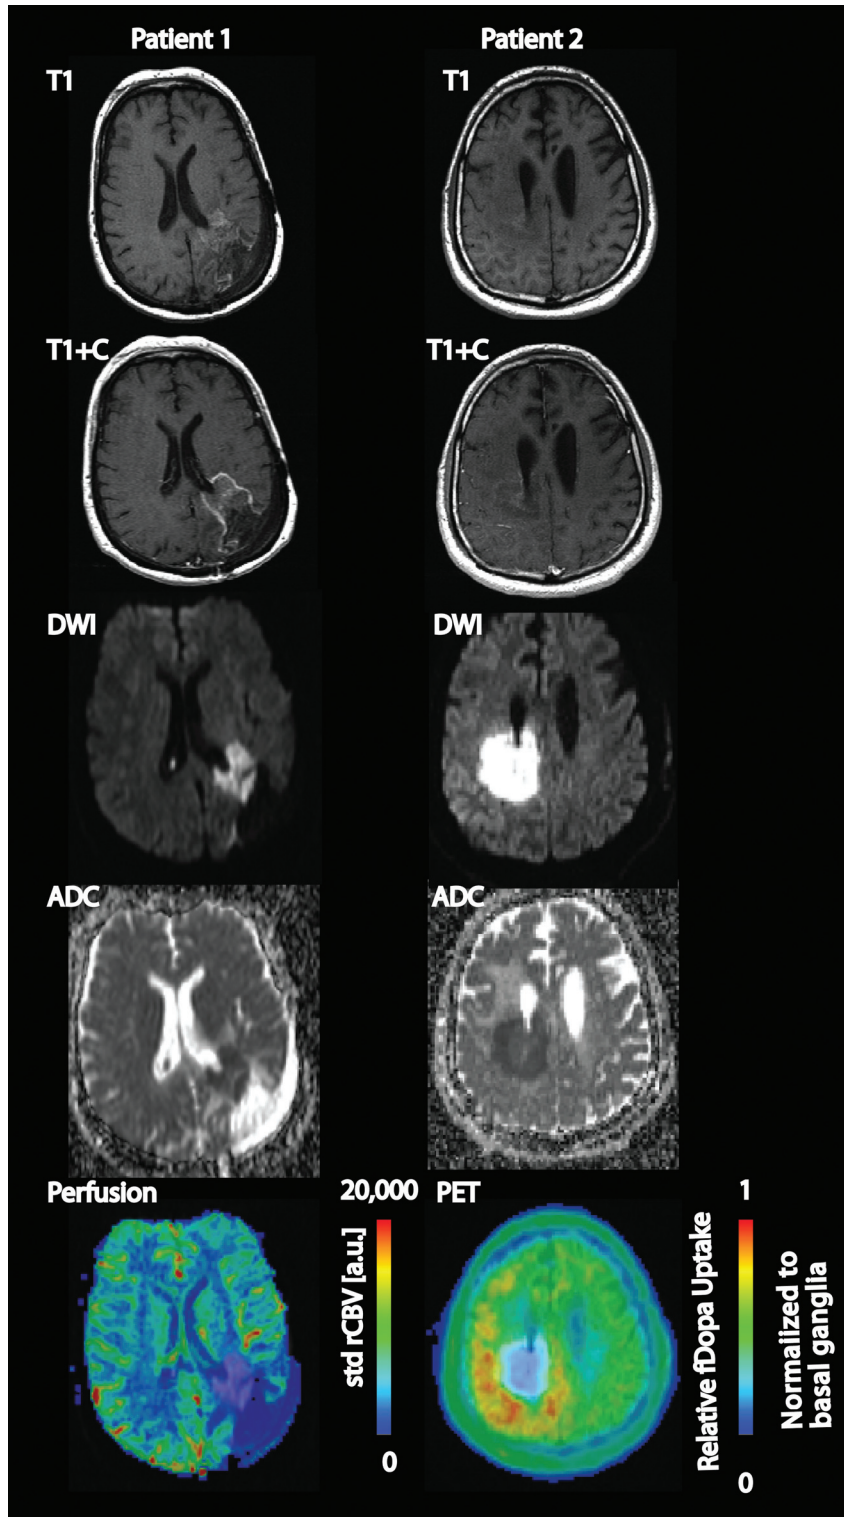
A representative low ADC lesion in a patient with glioblastoma demonstrates faint rim-enhancement on T1-weighted MR imaging with and without contrast, low signal intensity on ADC, hyperintensity on DWI, and hypermetabolic activity on ^{18}F -FDOPA PET scans. The standardized rCBV in the region of interest (normalized to normal-appearing white matter) was 0.44 in this patient. The legend shows standardized rCBV scaled 0–20,000 astronomical units. Another representative lesion demonstrates the above features, as well as hypoperfusion on a DSC perfusion MR imaging. The legend shows relative ^{18}F -FDOPA uptake with the standardized uptake value (SUV) normalized to basal ganglia, with the mean SUV in this patient of 0.43.
